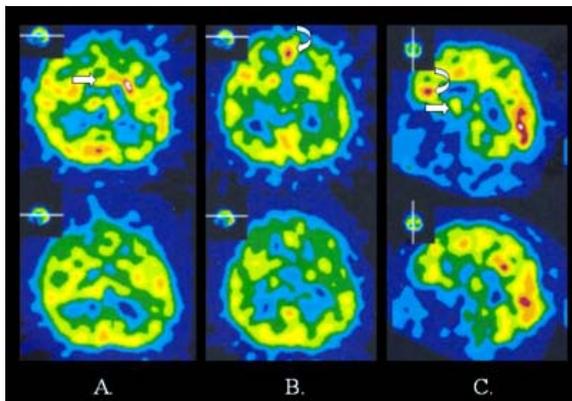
Ictal (upper row) and interictal (lower row) SPECT images: The midline hypothalamic region showed hyperperfusion on the ictal study compared to hypoperfusion on the interictal study (straight arrow). The medial frontal area near the frontal pole showed hyperperfusion on the ictal and normoperfusion on the interictal study (curved arrow)
